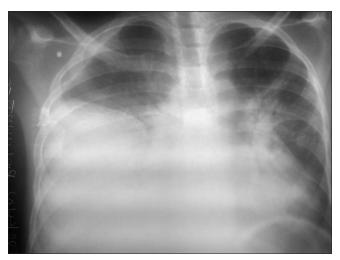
Chest X-ray showing right-sided homogenous opacity (pleural effusion)
